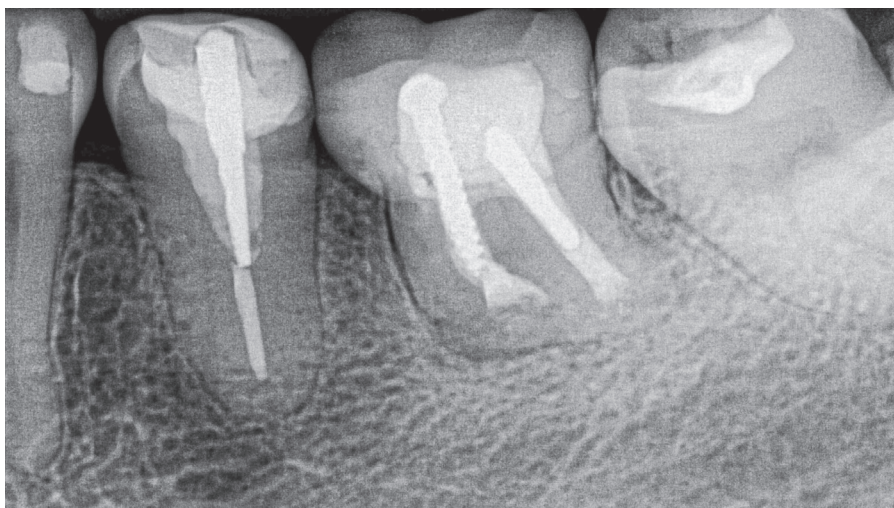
Periapical radiography where note the presence of the gutta-percha cone outside of the channel limits, in the mesial root.
